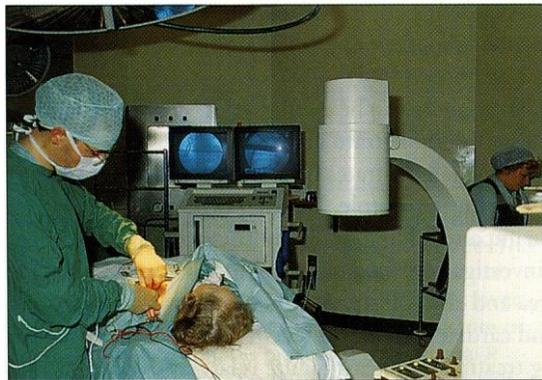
The cardiac catheter laboratory. Catheters may be advanced to the left and right heart in aseptic conditions and under X-ray control. Angiography and an increasing number of interventional techniques, including ablation of abnormal conduction pathways, may be performed, in addition to pressure and oxygen saturation studies.
